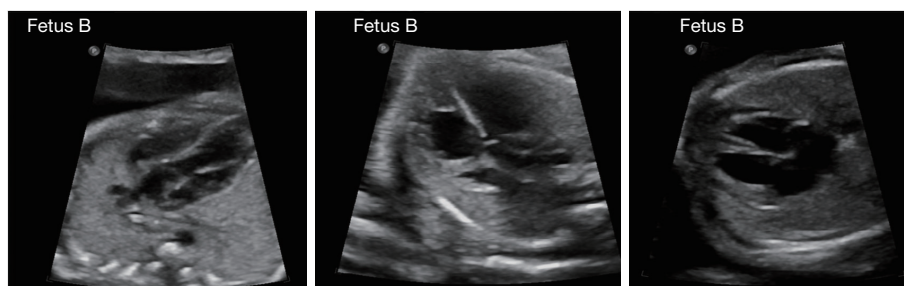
Fetal echocardiography images twin B with dextro-transposition of the great arteries (case 2).
